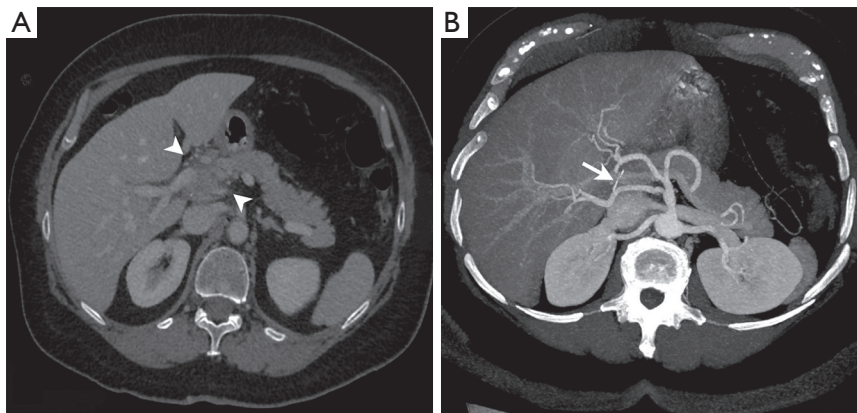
Axial cross-section of abdominal contrast-enhanced CT scan (portal time) brought to light a tissular density mass (arrow heads) at the level of hepatic hilum and surrounding portal vein and hepatic arteries (A). Reformatted CT images in maximum intensity projection (MIP) visualization mode showing a thin linear hyperdense structure (arrow) in close contact with hepatic vessels in the hepatic hilum region (B).
